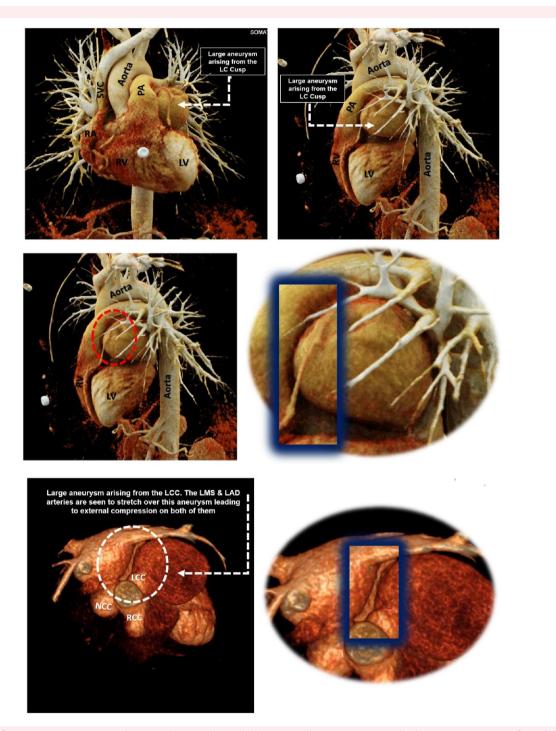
A 3D reconstruction computed tomography scan showed dilatation in all coronary cusps with a huge aneurysm arising from the left coronary cusp. The LMS and LAD are seen to stretch over this aneurysm causing external compression on both the left main stem and left anterior descending artery. The remainder of the aorta including the main arch vessels appear satisfactory and normal with no dilatation and no calcified atheroma. LAD, left anterior descending artery; LCC, left coronary cusp; LMS, left main stem; LV, left ventricle; NCC, non-coronary cusp; PA, pulmonary artery; RA, right atrium; RCC, right coronary cusp; RV, right ventricle.
